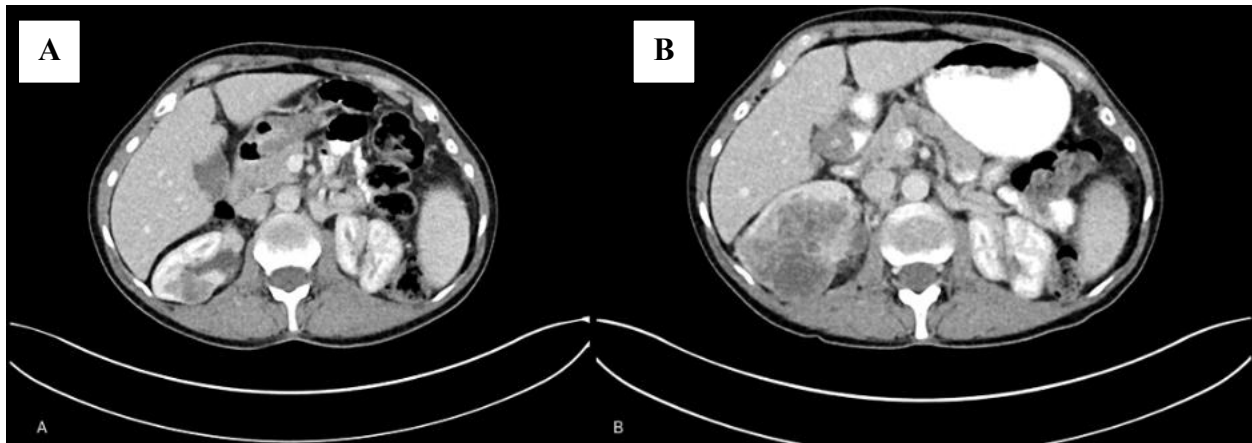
(A) Axial and (B) coronal computed tomography images of the abdomen and pelvis with intravenous contrast displaying tumor invasion within the renal pelvis, right renal vein, and inferior vena cava with 50% luminal diameter narrowing.
